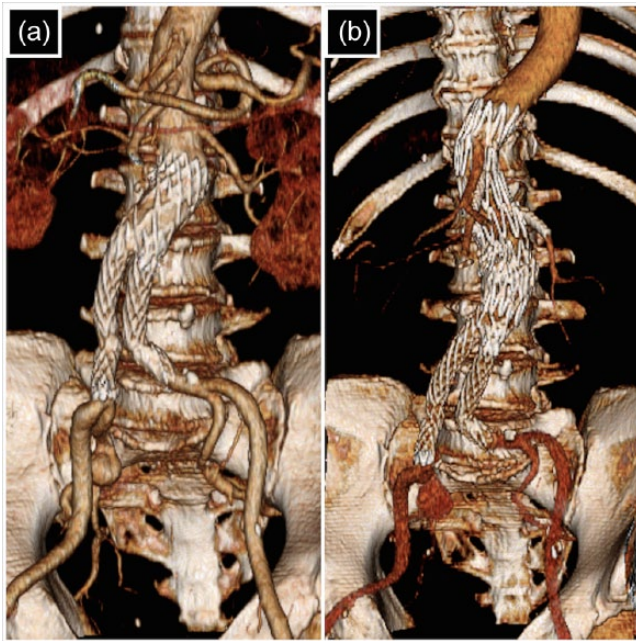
(a) Post-operative CT 3D reconstructions showing the initial aorto-bi-iliac Boston Vanguard graft. (b) Post-operative f-EVAR proximal extension.
